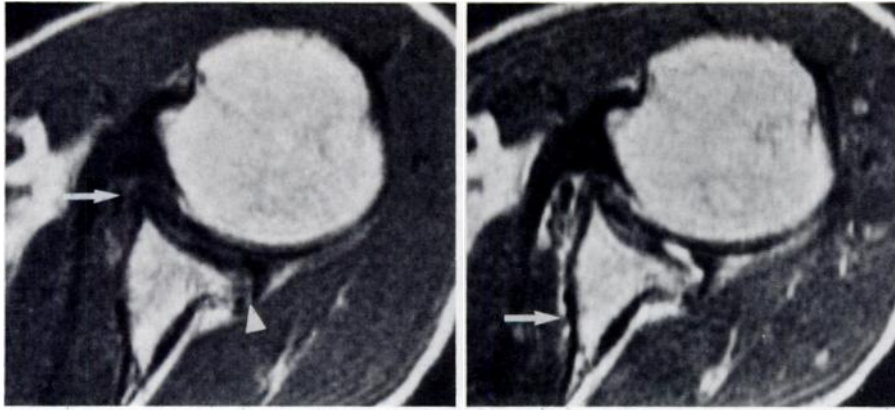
Anterior labral tear in a 20-year-old male baseball pitcher with 4-month history of anterior subluxation. (a) Axial T1-weighted image (SE 500/28) shows band of medium-intensity signal traversing anterior labrum (arrow). (b) T2-weighted image (SE 2,000/56) reveals high-signal-intensity joint fluid surrounding anterior labrum and within tear. Surgery disclosed "bucket-handle" tear anteriorly. Thin band of intermediate signal intensity adjacent to posterior labrum (black arrowhead) represents articular cartilage. More posterior rim of intermediate signal intensity (white arrowhead) is believed to represent the thin layer of cartilage tissue at the labral base. The signal is not high enough on this T2-weighted image to represent fluid due to tear. Posterior labrum was normal at surgery.
